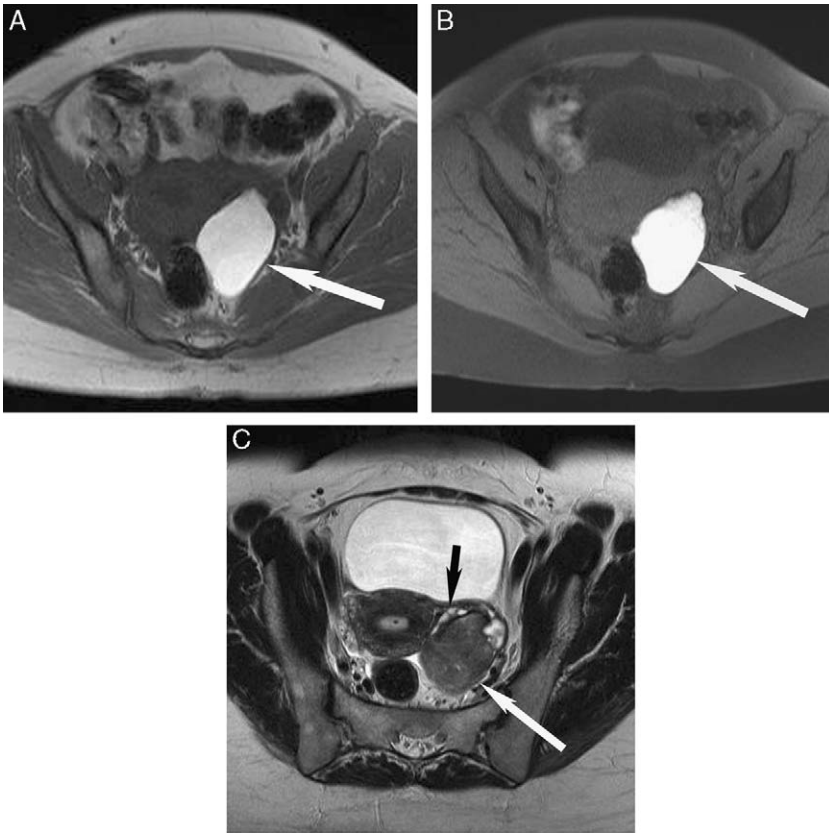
Endometrioma, magnetic resonance imaging. (A) Axial, nonfat suppressed T1-weighted MR shows a large, unilocular, high-signal lesion (arrow), which remains bright (B), with fat suppression. (C) The T2-weighted image shows classic loss of signal intensity “shading” (white arrow), which is from the concentrated blood products within an endometrioma. Small peripheral ovarian follicles are also noted (black arrow).
